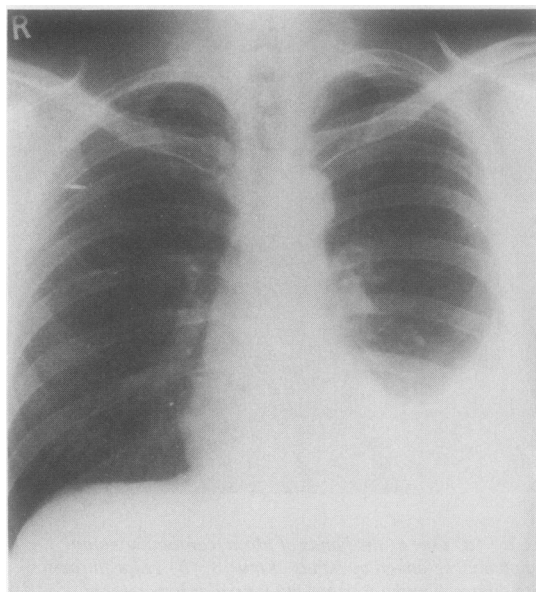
Chest radiograph at admission, showing left sided pleural effusion.
